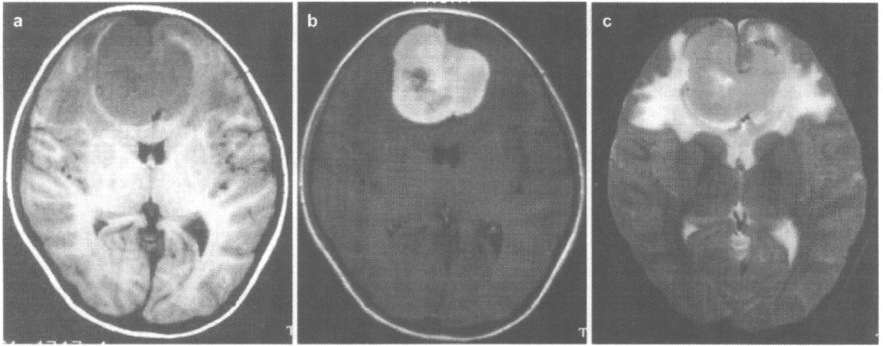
Magnetic resonance (MR) images obtained at initial presentation. a T₁-weighted image showing the midfrontal large tumor. b The tumor was homogeneously enhanced by gadolinium. c T₂-weighted MR image of the tumor with massive peritumoral brain edema
